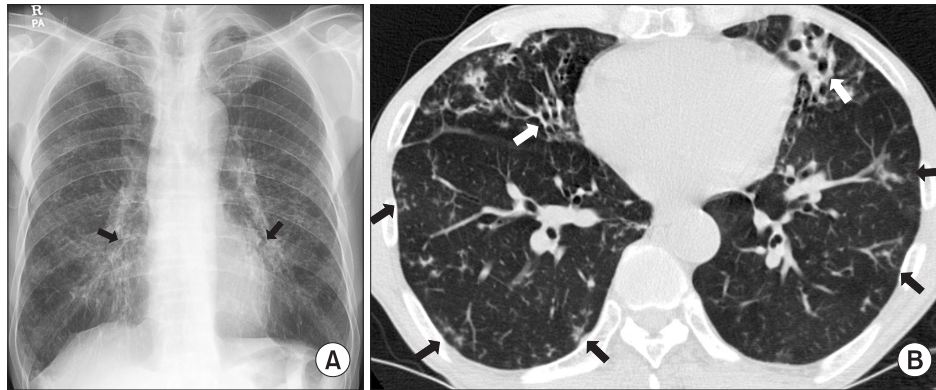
A 66-year-old male with bronchiectasis and nontuberculous mycobacterial lung disease caused by *Mycobacterium abscessus* subsp. *bolletii*. (A) Chest radiography revealed bilateral multifocal tram-track signs (black arrows), suggesting bronchiectasis. (B) A transverse chest computed tomography scan (3.0-mm-section thickness) revealed bilateral bronchiectasis (white arrows) in the middle right lobe and the lingular segment of the upper left lobe as well as multiple tree-in-bud appearances (black arrows), suggesting bronchiolitis in both lungs.
